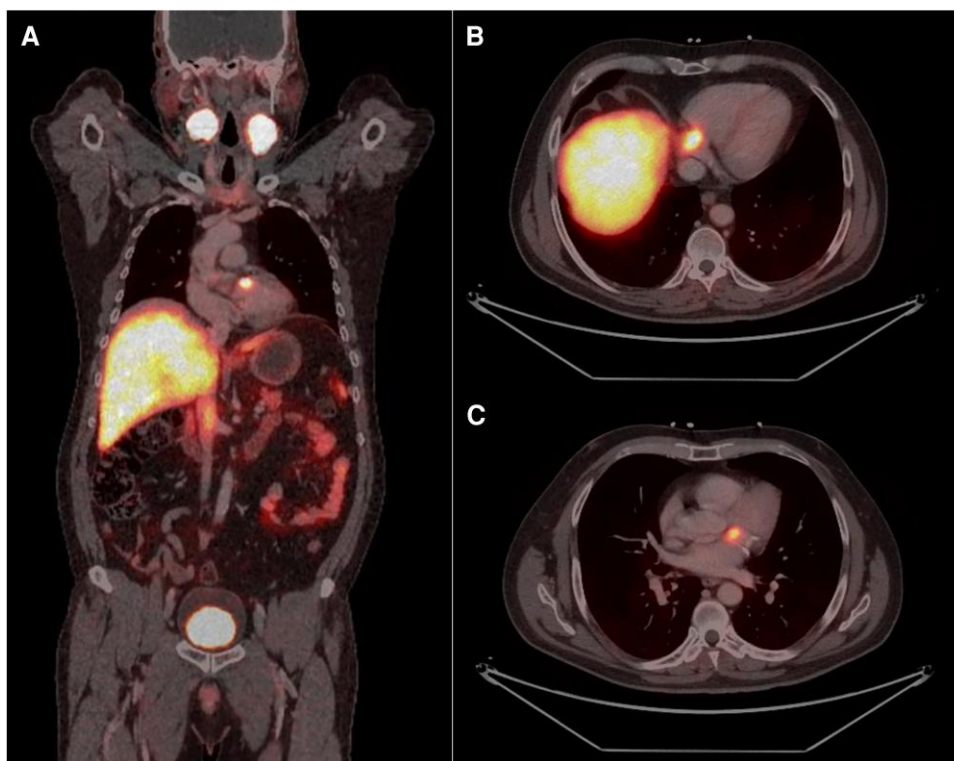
The images obtained in the gallium ^{68}Ga -edotreotide PET/CT study are shown. A, Lesions located at the bifurcation of both common carotid related to bilateral carotid PGLs. B and C, In the chest, focal areas of increased uptake are shown in the right coronary sulcus, B, at the distal segment of the right coronary artery, and another, C, in contact with the adjacent circumflex artery anterolateral to the left atrium, both suggestive of cardiac PGLs.
